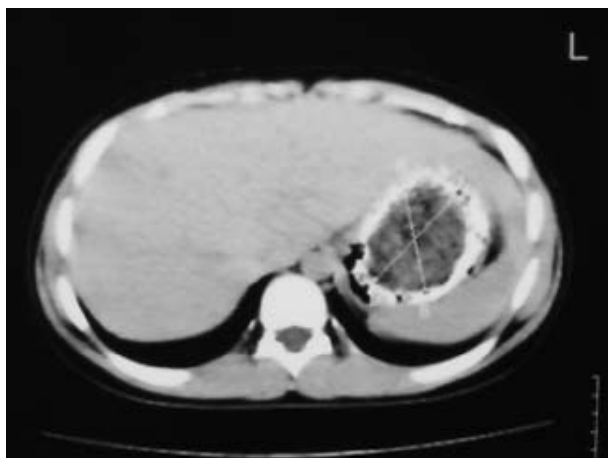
Abdominal CT, after an oral contrast, in the supine position, showing non-adherent mass at the fundus level.
